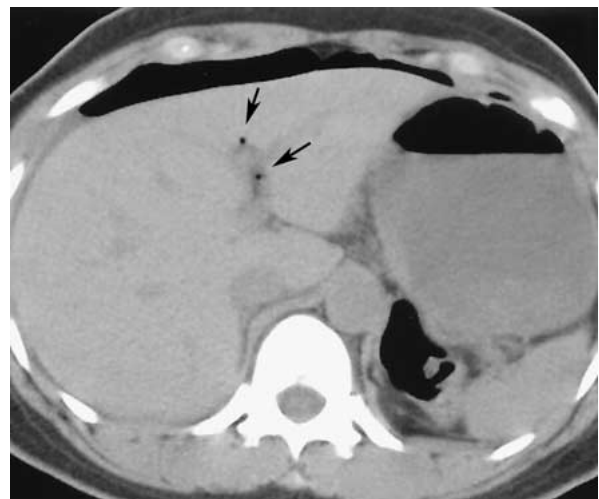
Contrast-enhanced CT image of duodenal bulb perforation. Air in the intrahepatic fissure for the ligamentum teres is visible (*arrows*). Peritoneal fluid and free air in the anterior peritoneal surface of the liver are demonstrated.
